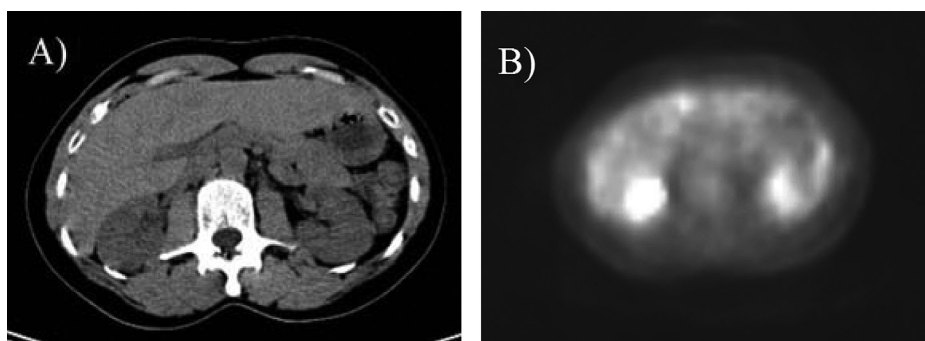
Representative PET/CT image. (A) CT and (B) ^{18}F -FDG PET image sets.
